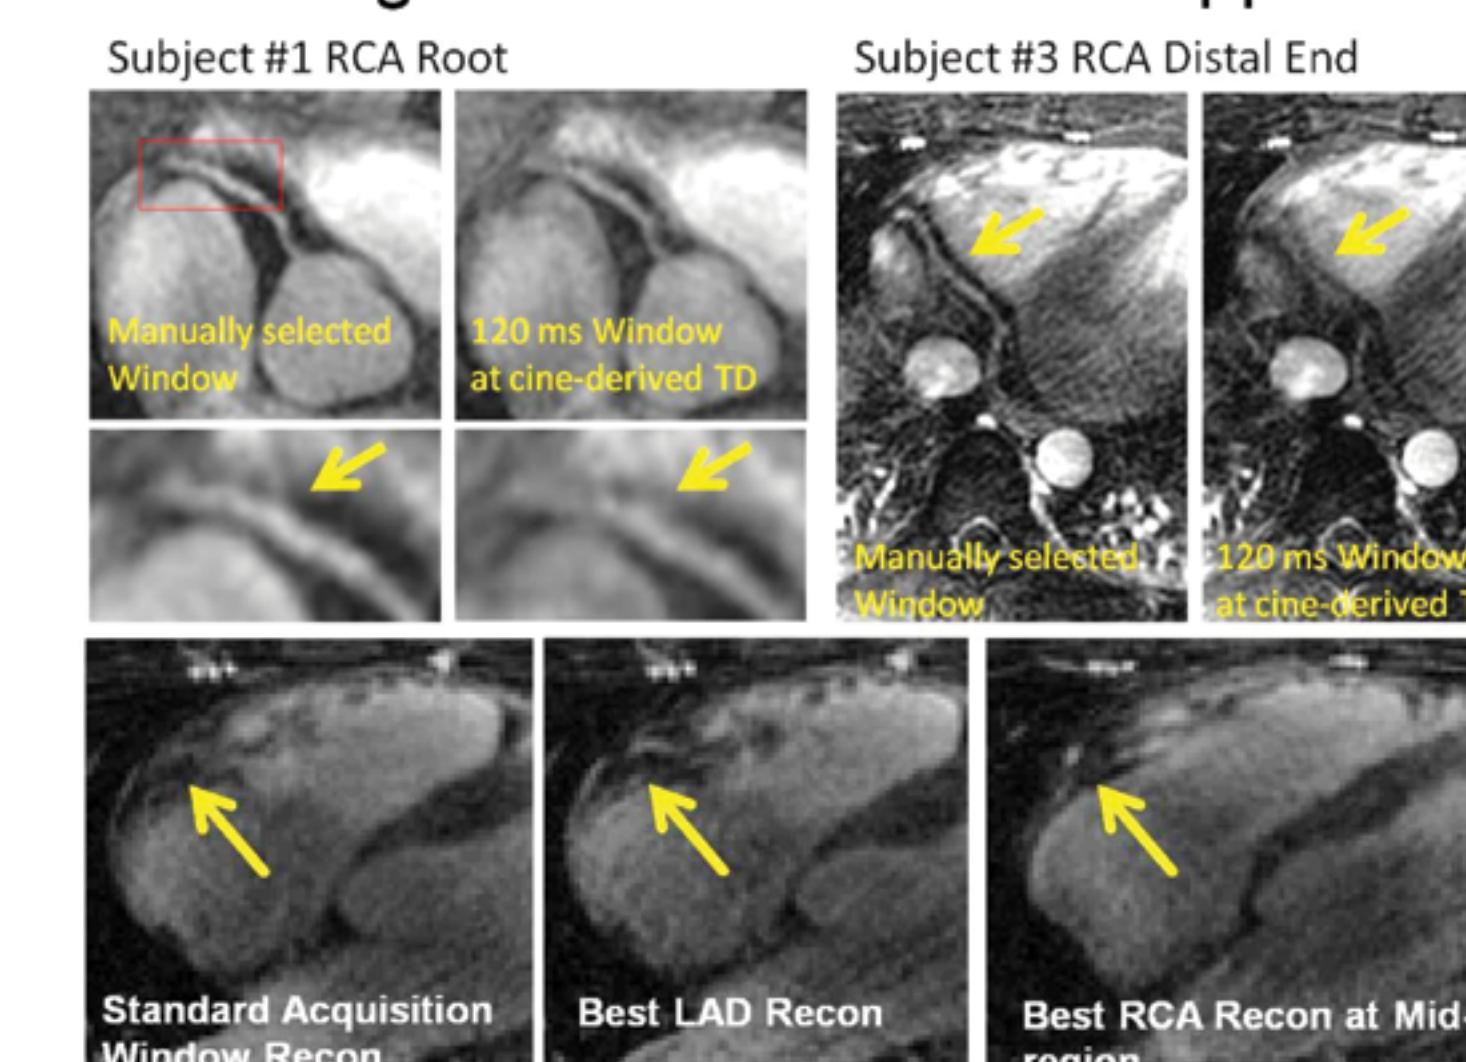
(Top row) Two Examples of image quality improvement achieved with the proposed method that allows interactive adjustment of the MRI temporal window for reconstruction.
